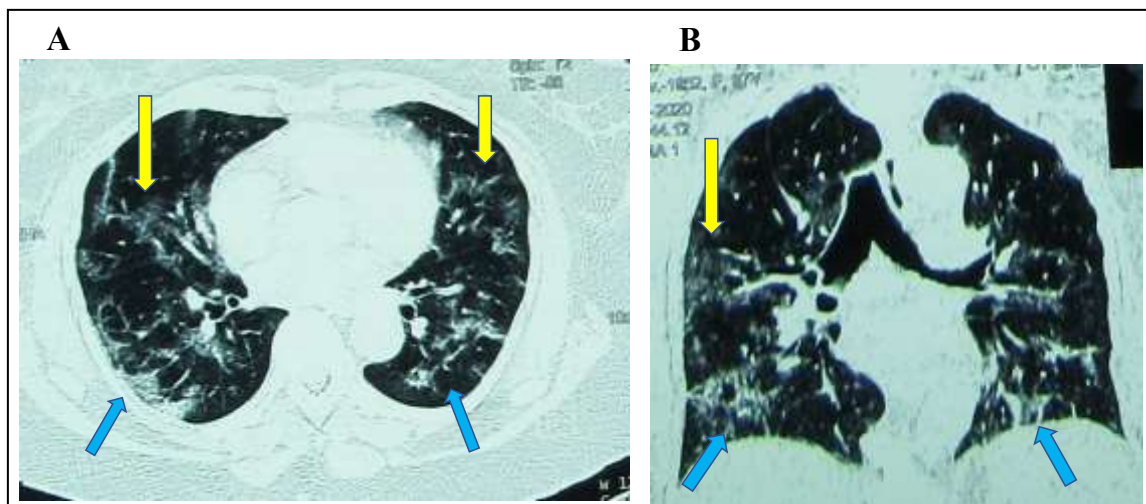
Representative chest CT scan images of moderate form of COVID-19 pneumonia with lung damage between 10-15% on chest CT scan without injection of iodinated contrast medium. (A) Axial and (B) sagittal view lung windows showing images of subpleural consolidation predominant in the right base (blue arrows) and diffuse ground glass (yellow arrows).
